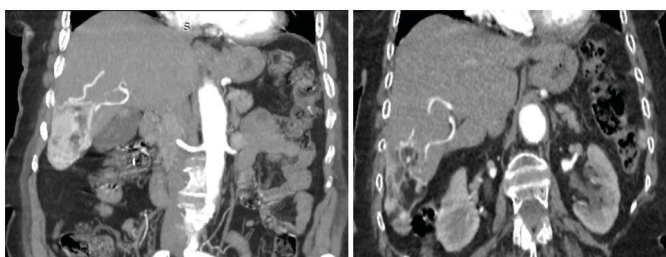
Coronal reformation of an abdominal CT in arterial phase: dysplastic vascular network arising from the hepatic artery.
